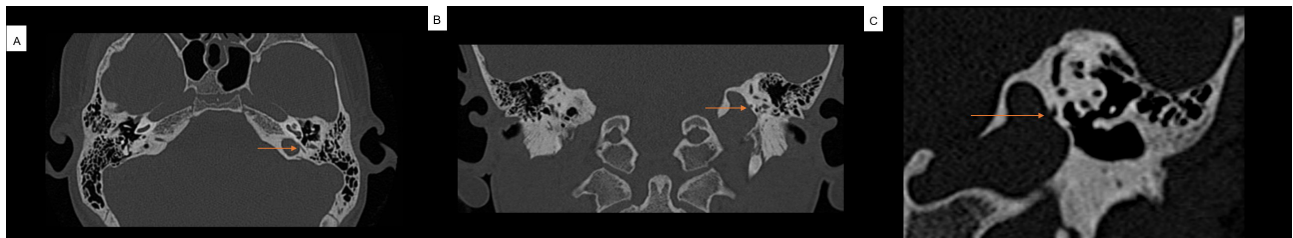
Head CT of patient J.G.G.C., performed in Joinville, Santa Catarina, 2023. A- Axial plane section of the mastoid region. B- Coronal plane section of the mastoid region. C- Oblique coronal plane section of the mastoid region. Red arrows point to the high left jugular bulb, which is associated with semicircular canal dehiscence in A, B, and C. This anatomical alteration, associated with the patient's tinnitus and hearing loss, suggests a diagnosis of posterior SCD.
